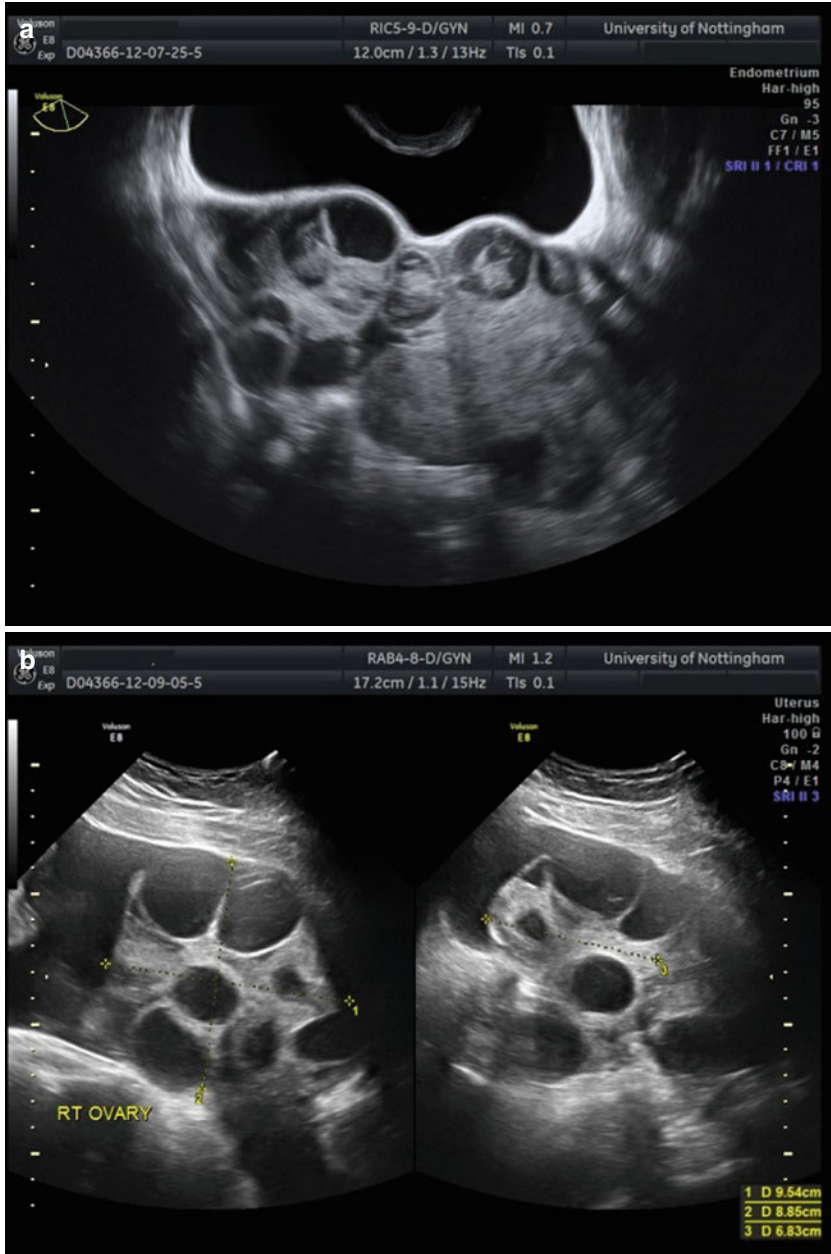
(a) Bilaterally enlarged ovaries following ART. Both ovaries are displaced superiorly above the uterus and are meeting in the midline ('kissing ovaries'). (b, c) Moderately enlarged ovaries following ART with post-ovocyte collection follicles of varying size. Some of the follicles contain clotted blood (arrow). (d) Post-ovocyte collection ovary. Note enlarged follicle with re-accumulated fluid and significantly increased vascularity as demonstrated by power Doppler modality. (e, f) Trans-abdominal scan of the right upper quadrant demonstrating the liver and right kidney (e). I cases of severe OHSS, free fluid can be seen in the pouch of Morrison (arrow). The left upper quadrant can also be filled with free fluid in severe cases of OHSS (f). Note free floating loops of bowel (arrow)
